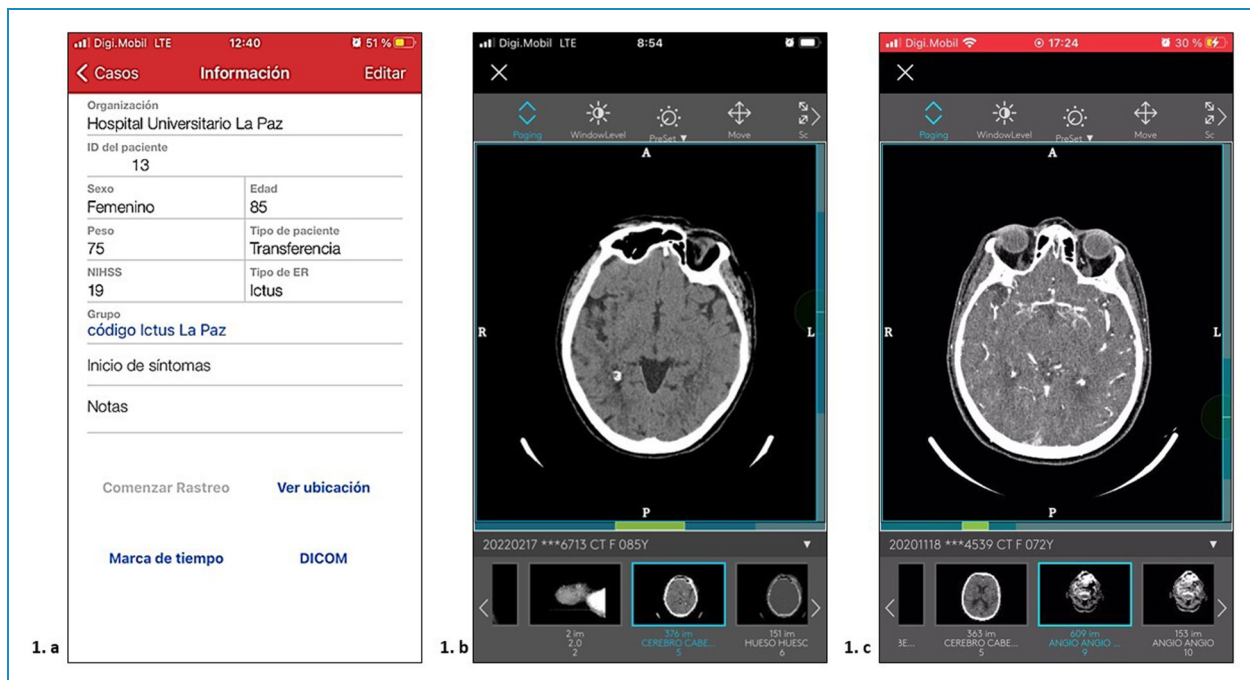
Screenshots of the app. (a) Main screen with patient data and links to the timestamps and DICOM images; (b) A cranial CT Scan view; (c) A cranial CT angiogram view.
